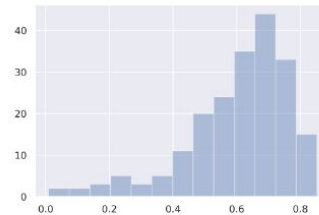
Count histogram of DSCs obtained by late 2D PET-CT fusion for the 4-center cross-validation.
